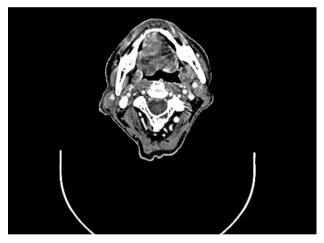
Head CT scan in axial plane. Tumor is adjacent to the mandibule but there are no signs of bone involvement.
